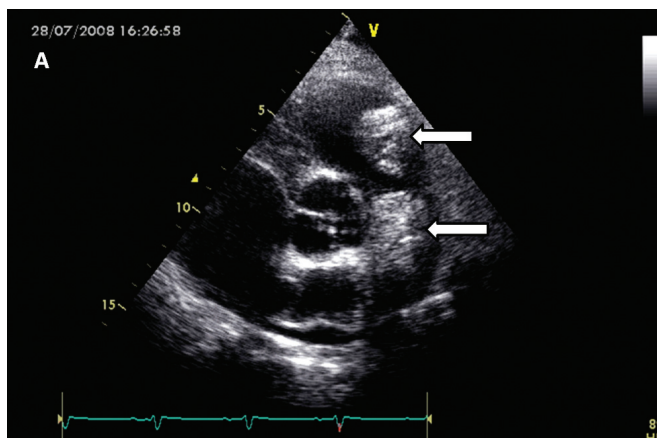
Transthoracic echocardiogram demonstrating 2 masses in the pulmonary artery (arrows), causing pulmonary hypertension.
